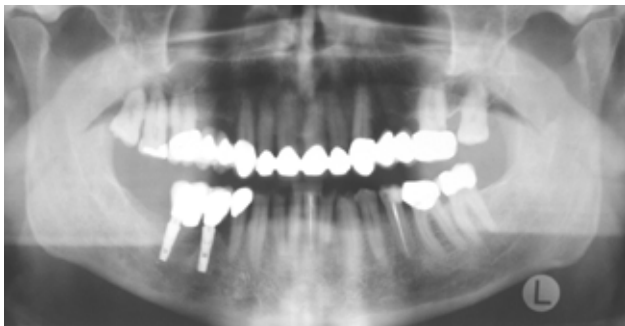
Panoramic radiography three years after implant placement.
